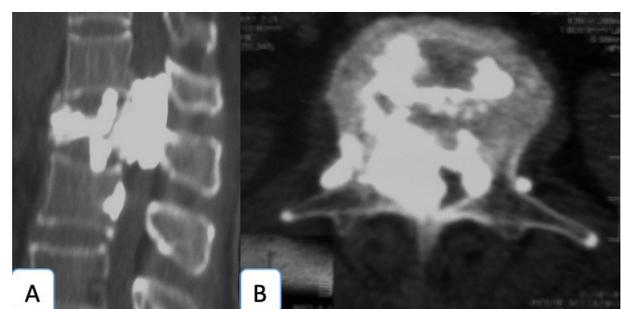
(A,B) Sagittal and axial CT lumbosacral spine of a 70 year old female with osteoporotic fracture L1. PVP was done with cement leak into the spinal canal with near complete occlusion. She developed paraparesis and required decompressive laminectomy. She showed gradual improvement in motor power after decompressive laminectomy and was able to walk after 6 months.
